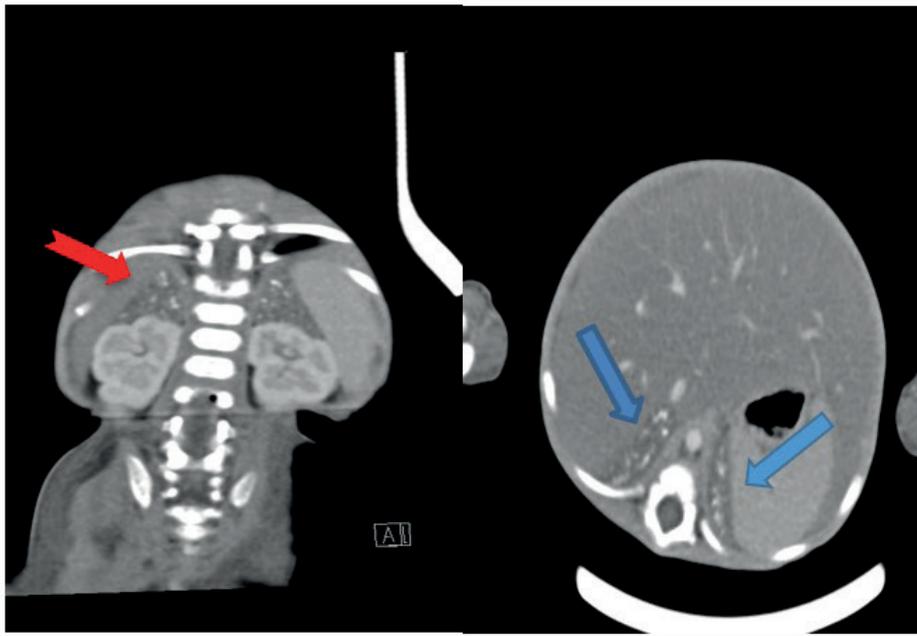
Coronal and axial view of the abdominal CT scan showing multiple adrenal calcifications (red and blue arrows).
